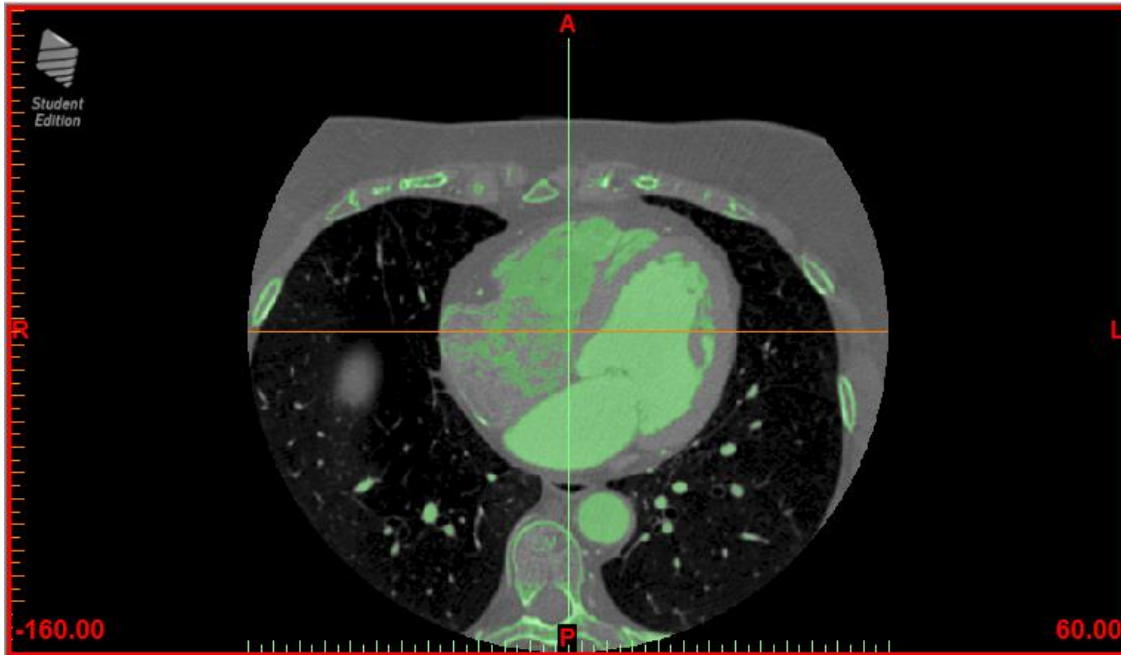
Original threshold of cardiac anatomy in the axial view, where A indicates anterior, P indicates posterior, R indicates right, L indicates left, 60.00 indicates slice number, and -160.00 indicates table position, which is the location of the examination table as the CT scanning proceeds.
